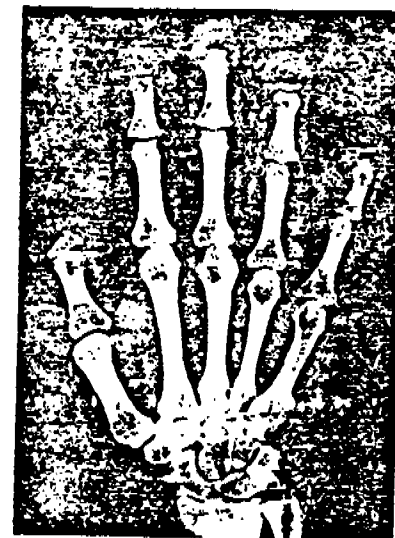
X-ray film of right hand showing acroosteolysis.
